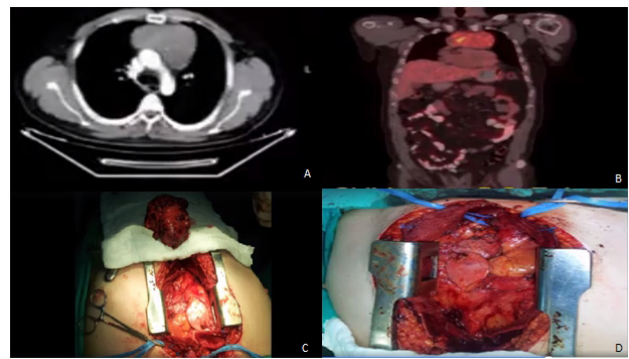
Toraks CT image of thymoma in anterior mediastinum (A). PET-CT image of thymoma with 7,5 SUVmax (B). Intraoperative image of TSET with thymoma (C). Intraoperative image of after TSET (D).
